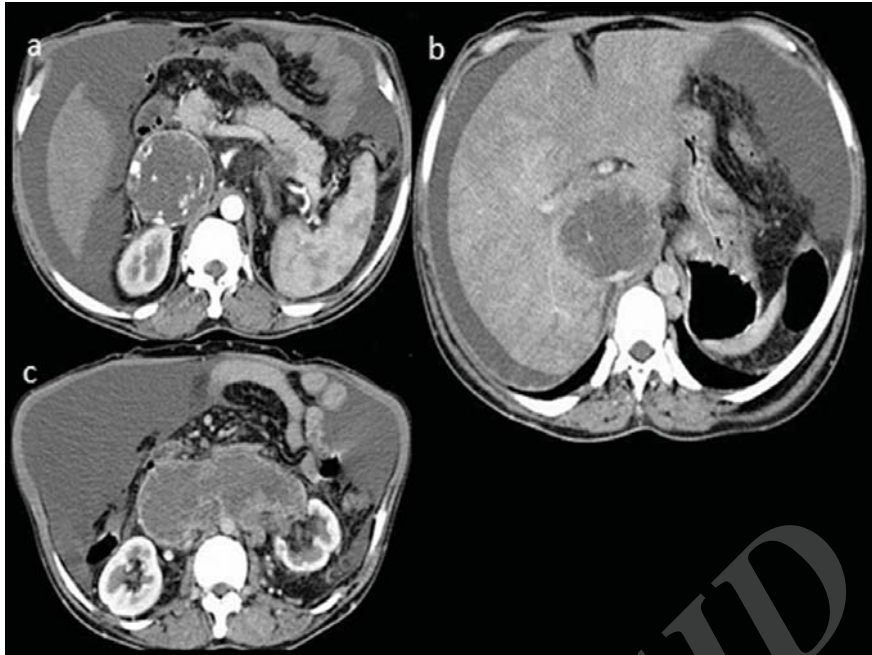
A 70-year male complains of abdominal distension and back pain. a) Arterial phase axial CT scan reveals neovascularity within IVC leiomyosarcoma; b) Venous phase axial CT scan reveals congestive hepatomegaly due to transhepatic IVC leiomyosarcoma; c) tumor thrombus extending in the left renal vein.
